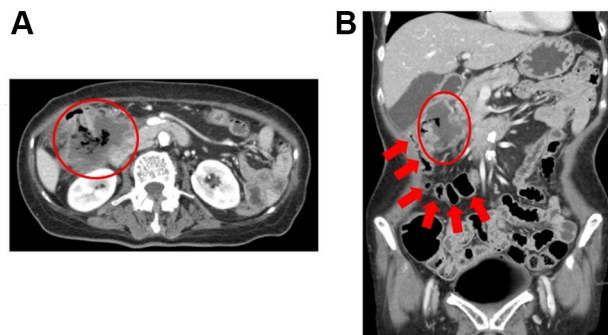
Abdominal computed tomography showing a large tumor near the transverse colon at the hepatic flexure. Axial image (A), and coronal plane (B). The tumor is surrounded by red circles. Red arrows indicate the transverse colon.
